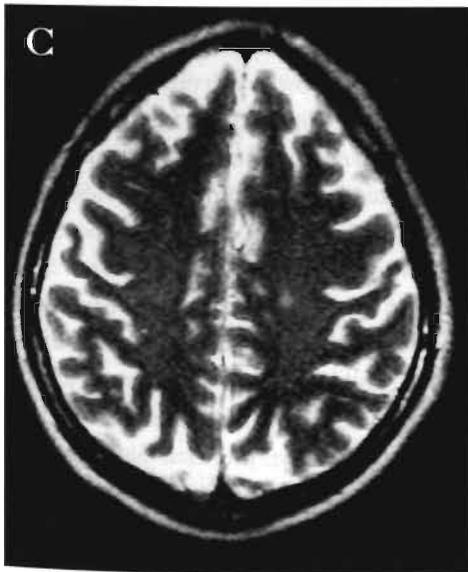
Magnetic resonance imaging of the brain in a 51-year old patient with neurological abnormalities at initial staging.
